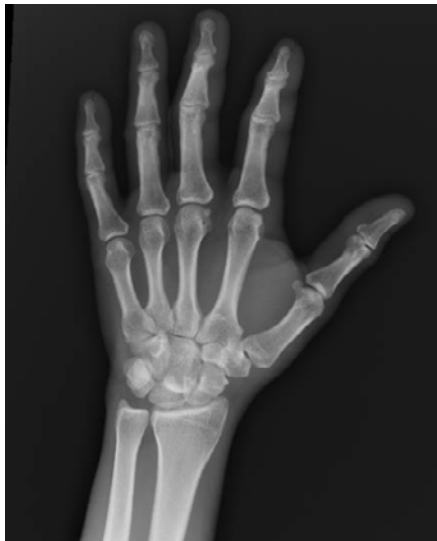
Anterior-posterior X-ray of the right hand after trauma. A right dorsal trans-scaphoid perilunate fracture dislocation is observed.
